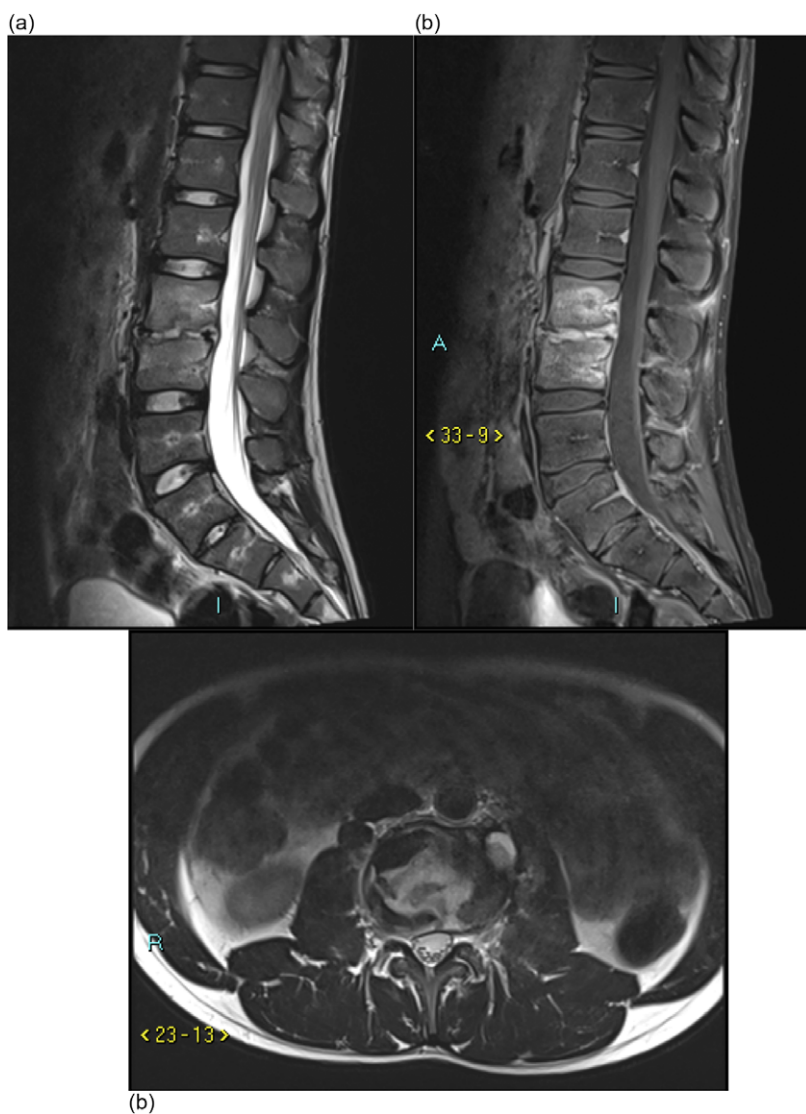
(a) Sagittal T2, (b) sagittal T1 with gadolinium enhancement and (c) axial T2 at level of interest MRI images lumbar spine
